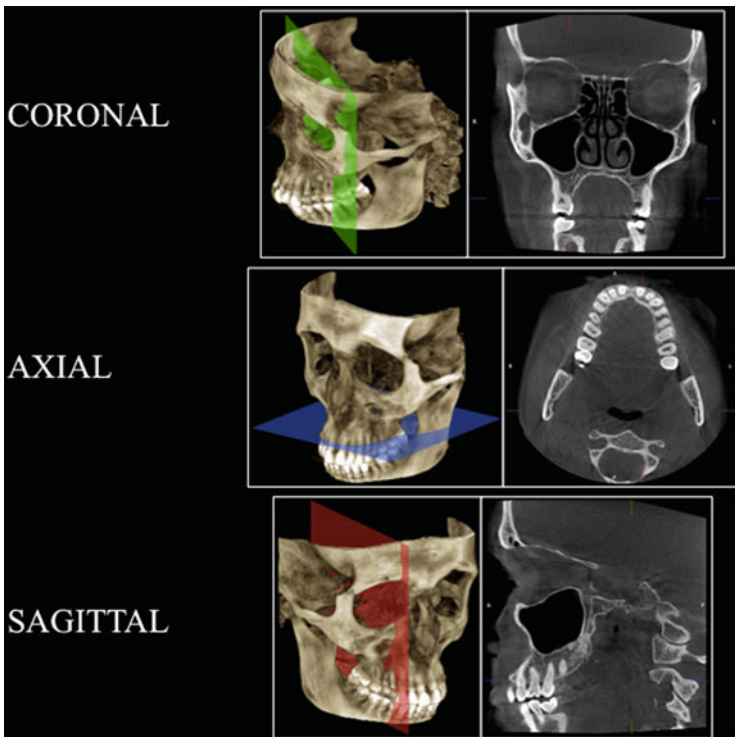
The three scan planes (on the *left*), and corresponding CBCT bidimensional scans (on the *right*)
